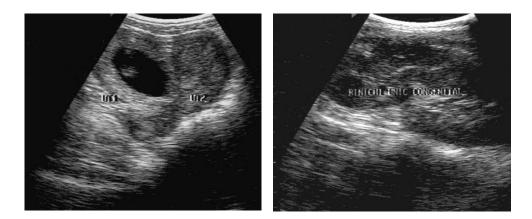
Unilateral agenesis associated with double uterus, 17 weeks pregnancy – ultrasound sections
